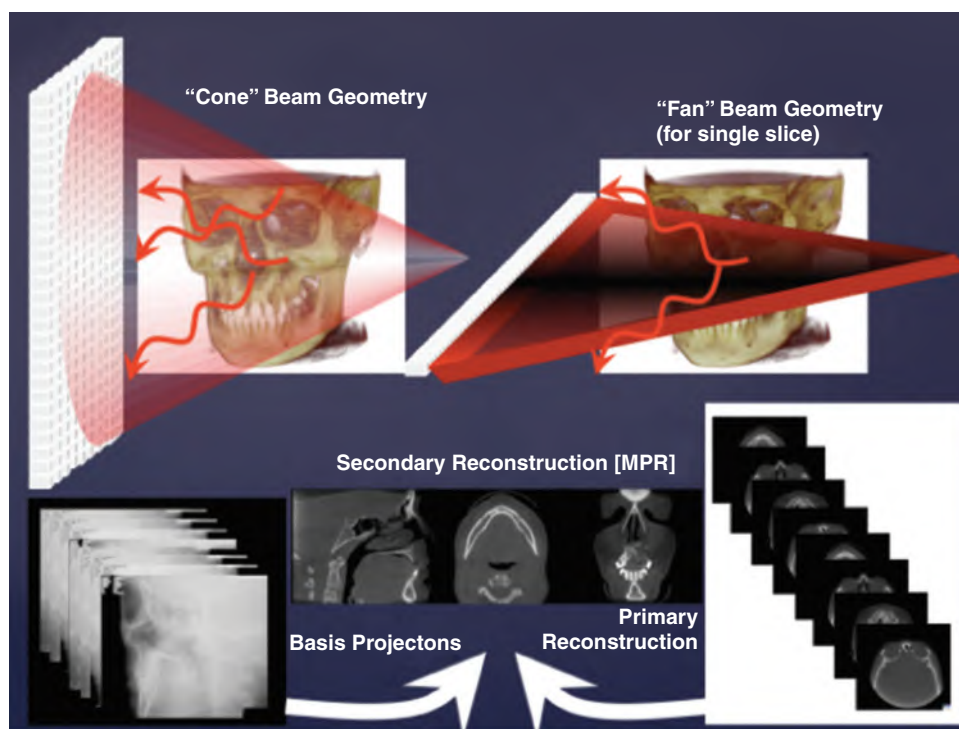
2 Comparison of CBCT and fan beam CT.
